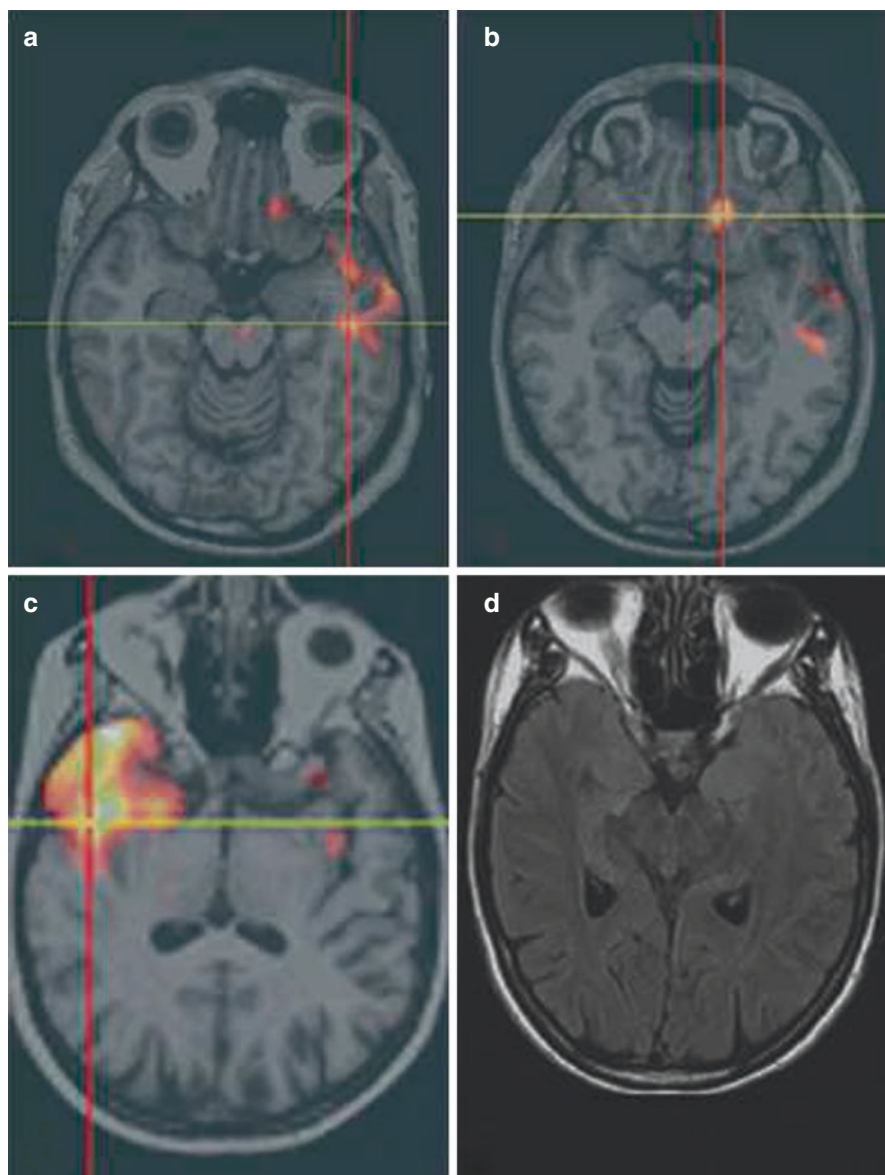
(a, b) Example of multiple SISCOM hyperperfusions which are concordant to multifocal ECoG (electrocorticography) seizure onsets: a 22-year-old male patient with drug-refractory epilepsy had two types of seizures. (c, d) Example of nonlesional MRI with SISCOM concordant to site of surgery and seizure-free outcome
